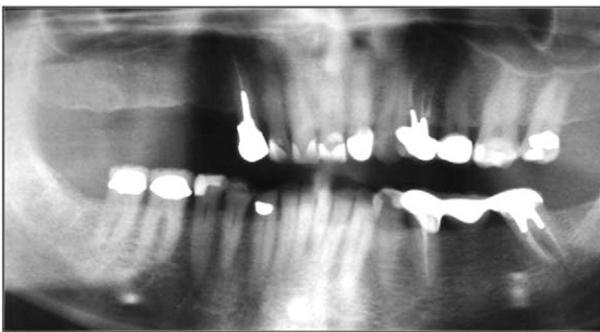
Preoperative panoramic radiograph showing edentulous right maxillary posterior region and proximity of maxillary sinus.
